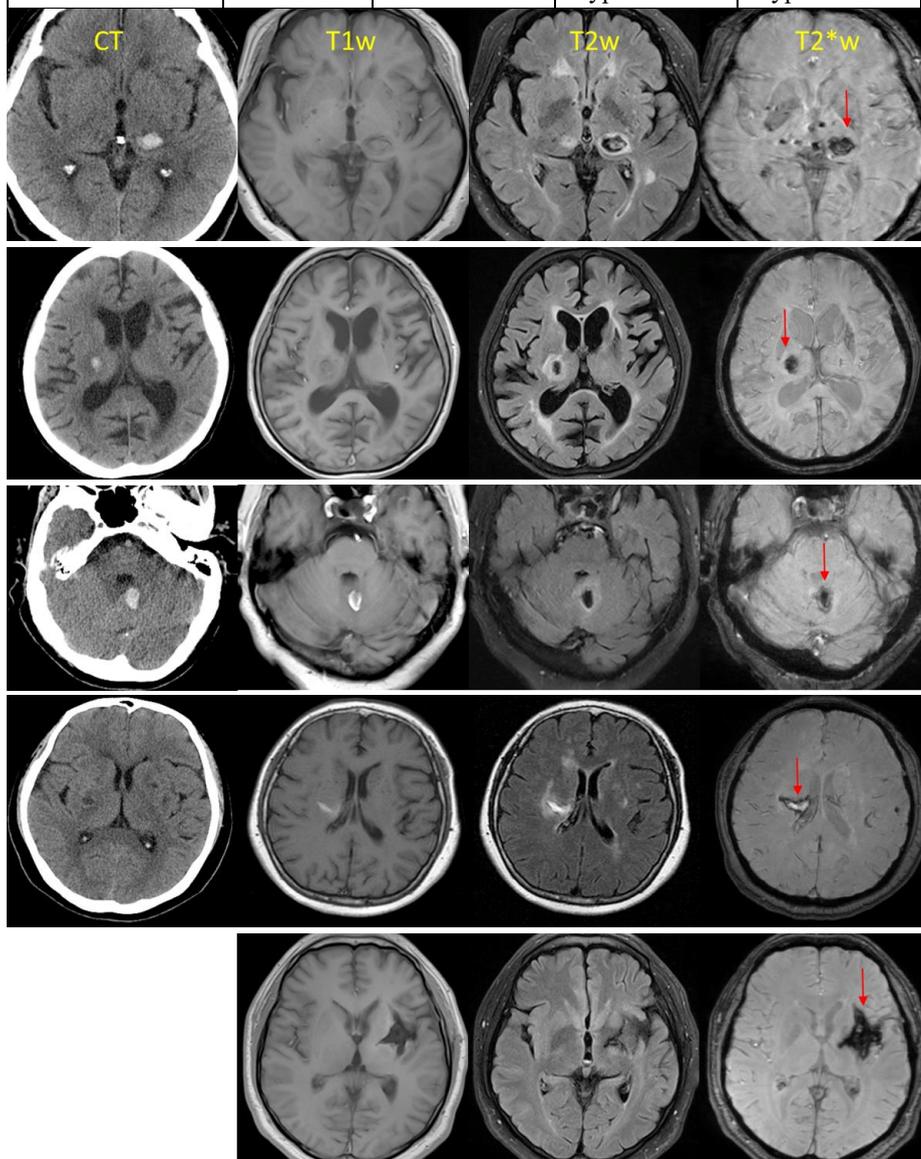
ICH at hyperacute (1st row), acute (2nd row), early subacute (3rd row), late subacute (4th row), and chronic (5th row) stages imaged with CT, and MRI with T1w, T2w and T2*w. These images are interpreted as follows:
